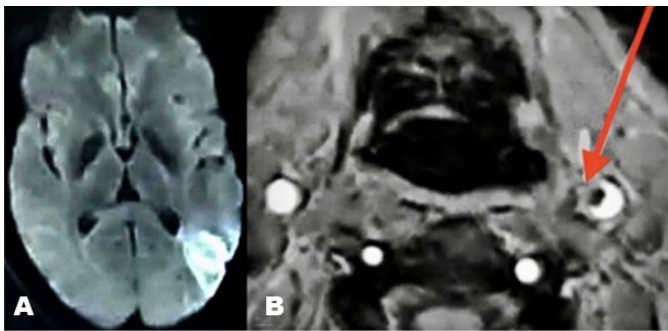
MRI and CTA of the patient. Image A shows diffusion weighted image showing the left parietal infarct. Image B is axial CT angiography image showing the FFT in the left proximal internal carotid artery (red arrow).
